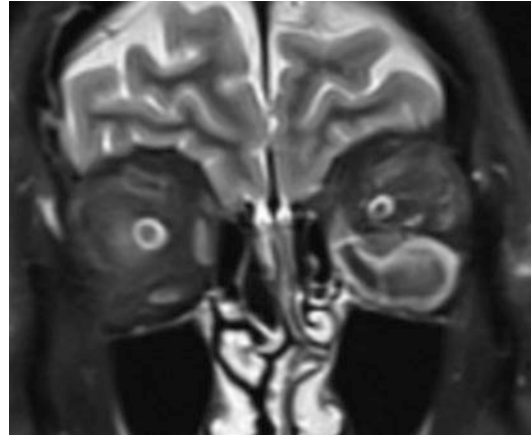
T2-weighted MR showing typical appearance of an acute haemorrhage, biased inferolaterally within the left orbit, it having a hyperintense 'capsule' surrounding the lower signal blood products
